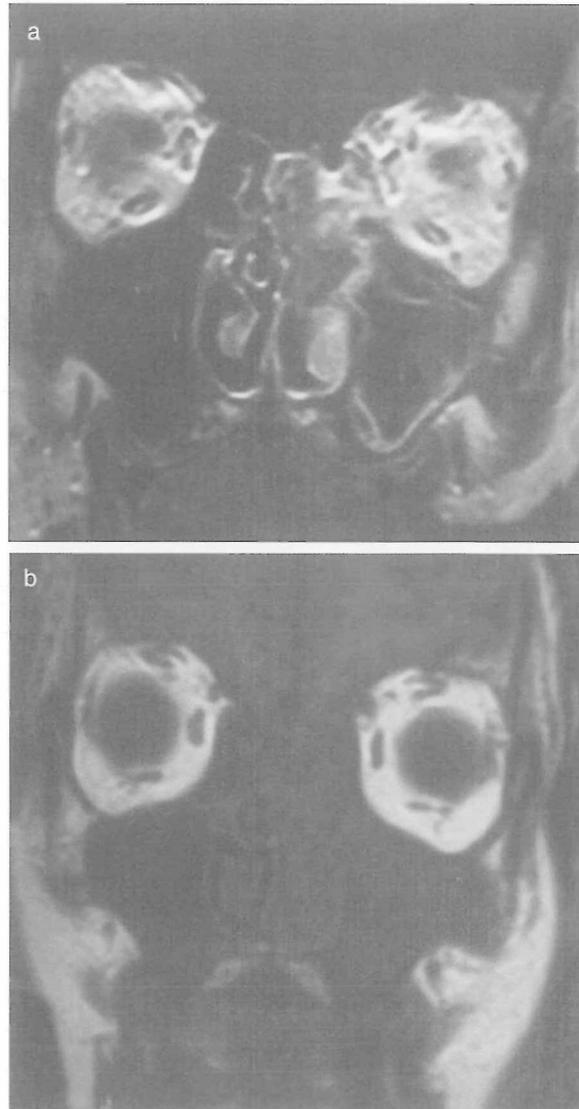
MRI of paranasal sinuses. Arrows show soft tissue mass, predominantly filling in the left nasal space on the coronal necks.
